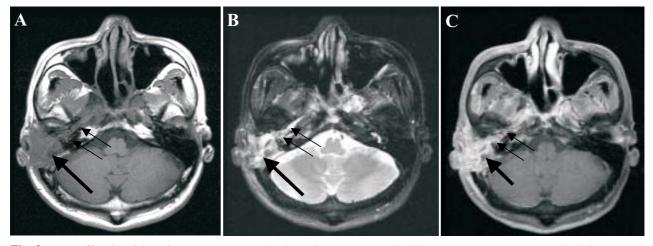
MRI of head, axial section. 2A: T1WI (TR/TE/NEX/MATRIX: 500/19/2/256X256); 2B: T2WI (4000/86/2/256X256); 2C: post-gadolinium enhancing T1WI (516/25/2/256X256). One relatively low SI soft tissue lesion was noted over the right side mastoid region (thick arrow) on T1WI (A), high SI on T2WI (B) with contrast enhancement on post-gadolinium images (C). An infiltrative lesion along the right side eustachian tube (double thin arrows) with similar image characteristic was also identified. The lesion was in contact with the right side mastoid lesion.
